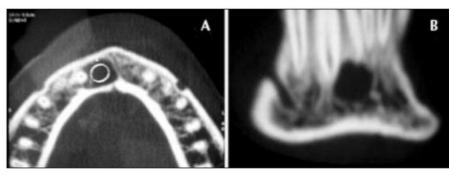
Sagital (A) and coronal (B) computed tomography images
